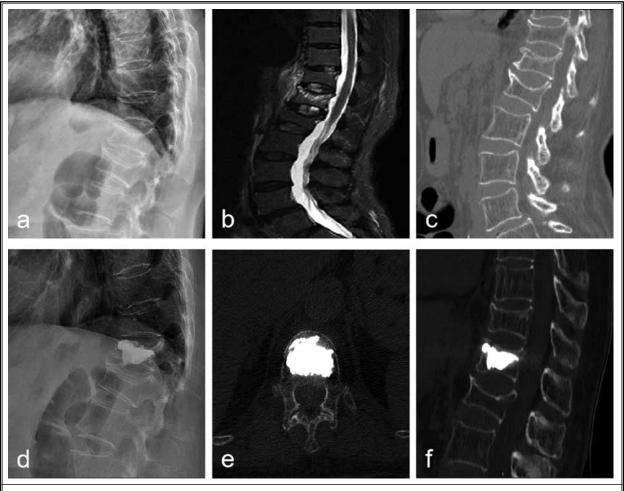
Preoperative and postoperative images in a case with osteoporotic compression fracture treated by PKP surgery under the assistance of a TINAVI surgical robot. (a) Lateral view of lumbar spine before surgery, compression fracture was shown at T11,12 and L1; (b) The fracture at T12 was new in MRI of lumbar spine before surgery; (c) Preoperative coronal CT of lumbar spine; (d) Lateral view of the lumbar spine after surgery; (e,f) Postoperative horizontal and coronal CT of the lumbar spine showed an even distribution of bone cement at T12 vertebral body.
